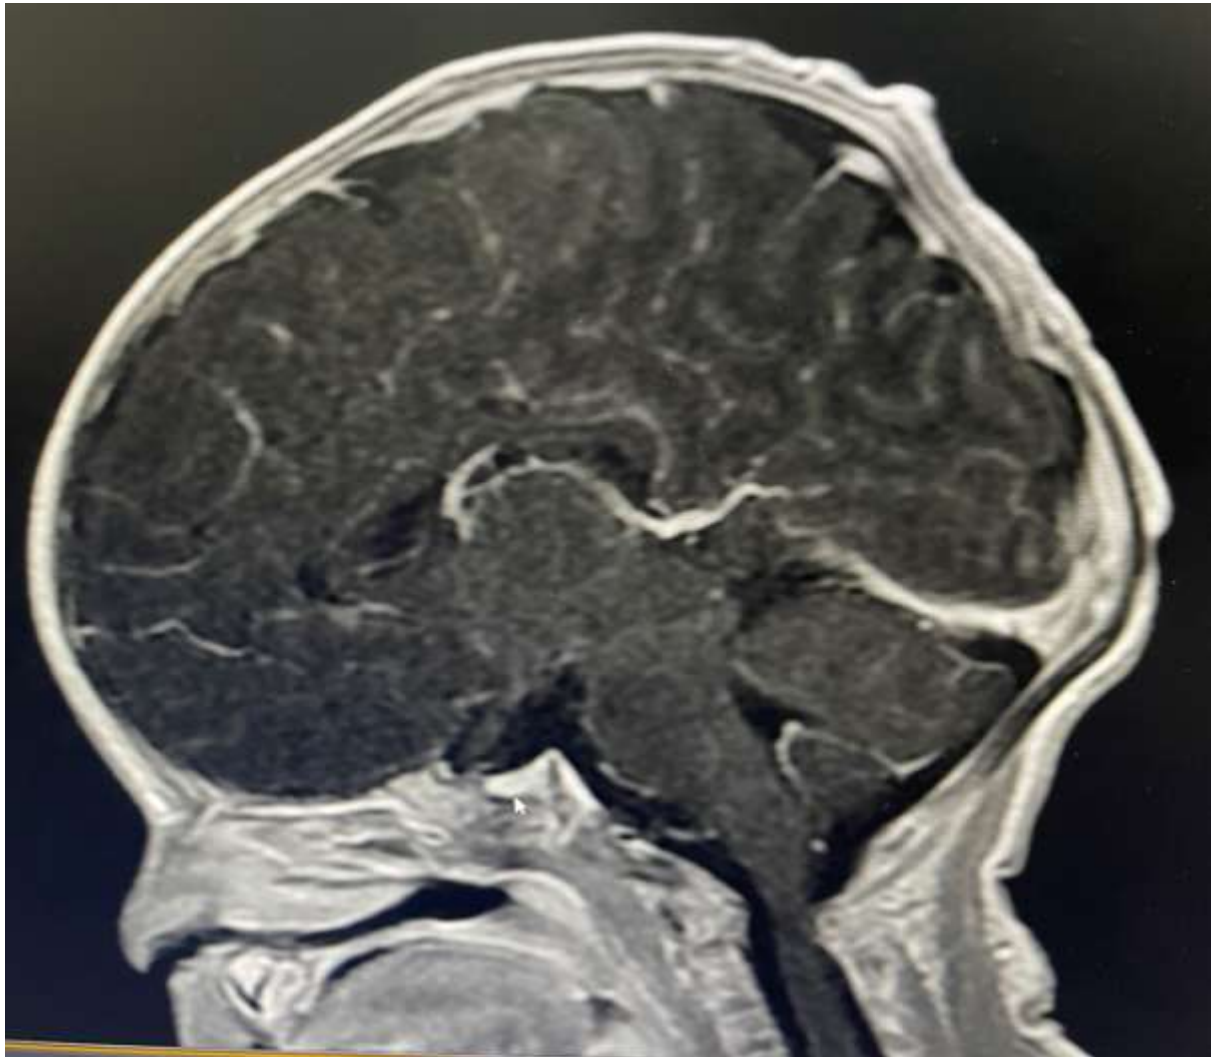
Magnetic resonance imaging (MRI) scan of the pituitary in our patient: The sagittal image showed complete interruption of the pituitary gland and an ectopic posthypophysis.
